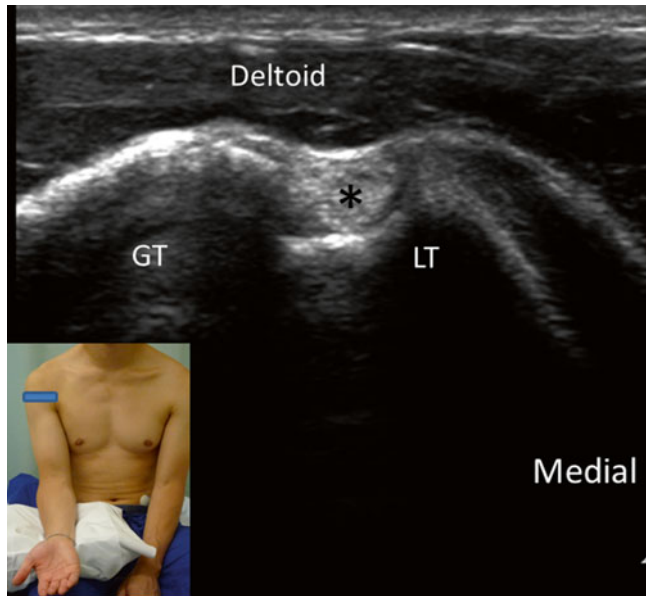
Sonogram of the long head of biceps (*) in the bicipital groove. Note that the tendon appears hyperechoic. The insert shows the position of the patient and the ultrasound probe. *LT* lesser tubercle, *GT* greater tubercle (Reproduced with permission from Philip Peng Educational Series)
